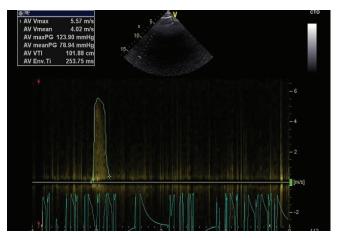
Prikaz VTI preko aortnog ušća i maksimalne brzine protoka u miru dobijene iz desnog parasternalnog preseka
